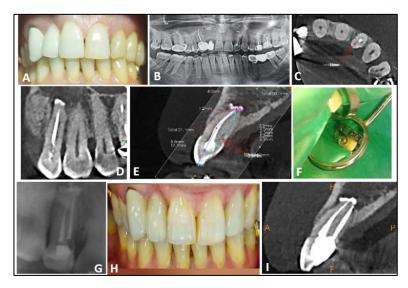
Preoperative intra-oral view, Figure B; Pre-operative Panoramic view, Figure C; Axial CBCT view shows both canal and the distance between them, Figure D; Coronal section of the CBCT image does not presents the second canal. Figure E; Sagittal section of CBCT image confirms the second palatal canal. Figure F: Rubber dame application with the access opening of the two canals. Figure G; Preapical x-ray after obturations. Figure H: Postoperative intra-oral view with the final filling. Figure I; Sagittal section of CBCT image after six months.
